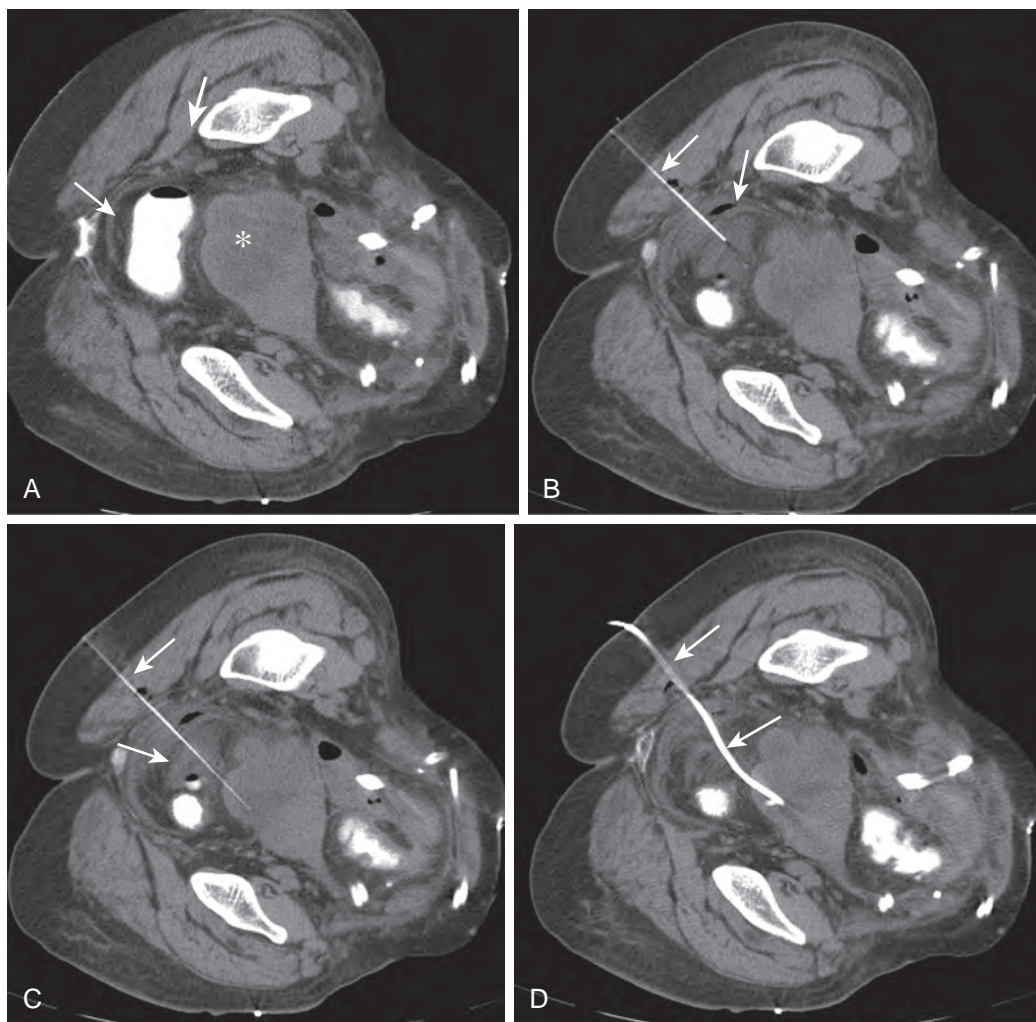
Hydrodissection technique for drainage of deep pelvic abscess. A. Preliminary CT image shows a deep pelvic abscess (asterisk). A safe pathway to the abscess is blocked by the rectum posteriorly (thin arrow). A lateral percutaneous access to the abscess (thick arrow) is hindered by presence of blood vessels. B. A 20-gauge Chiba needle was introduced lateral to the rectum, and saline (arrows) was instilled through the needle to displace the rectum medially. C. Subsequent CT image shows the needle placed into the abscess through the percutaneous path created by saline instillation (arrows). D. Procedural axial CT image shows a safe pathway created by hydrodissection, which allowed placement of the drainage catheter (arrows) into the abscess through the transgluteal approach.
